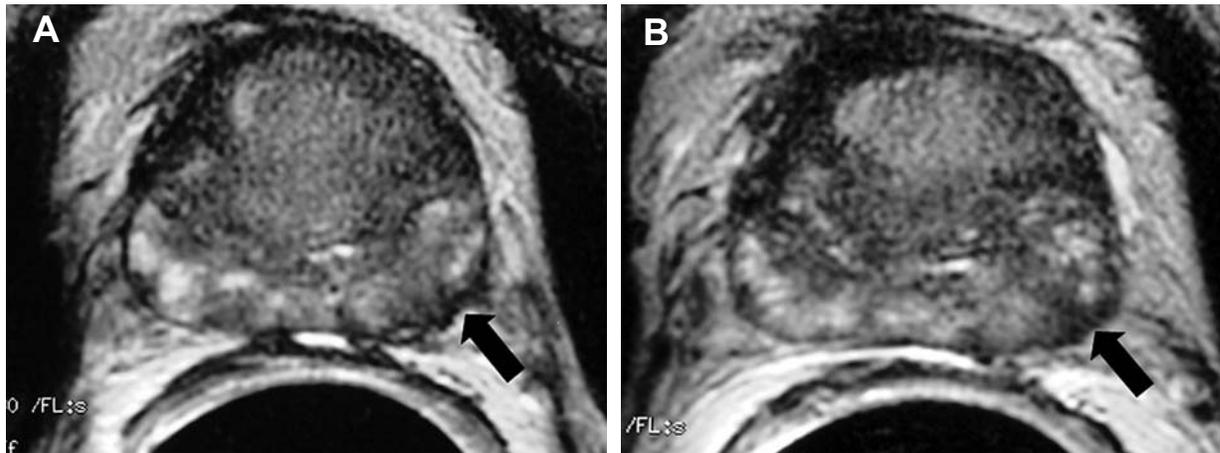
Prostate cancer. A) and B) E-MRI, axial plane, T2-weighted images showing focal area of low signal intensity in the lateral aspect of the left peripheral zone (arrow) associated with irregular thickening of the capsule of the prostate. TRUS-guided biopsy directed by these findings, allowed the diagnosis of prostate cancer; Gleason score (3+4).
